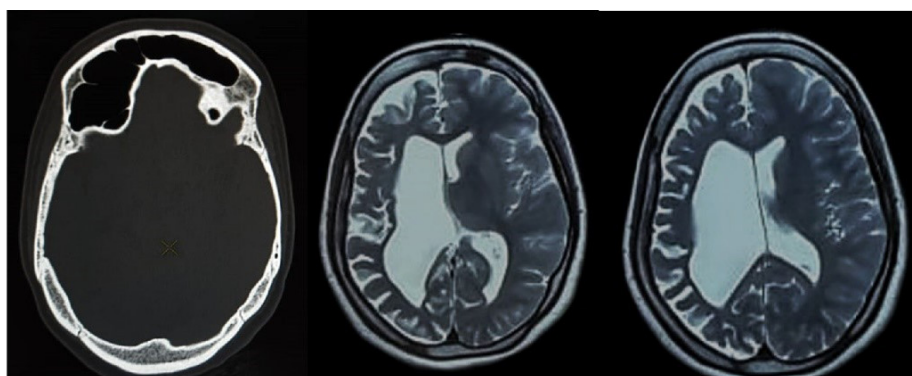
CT Scan and MRI Showing Hemiatrophy of the Right Cerebral Hemisphere With Right Sided Cortical Thickening and Dilated Right Frontal Sinus
